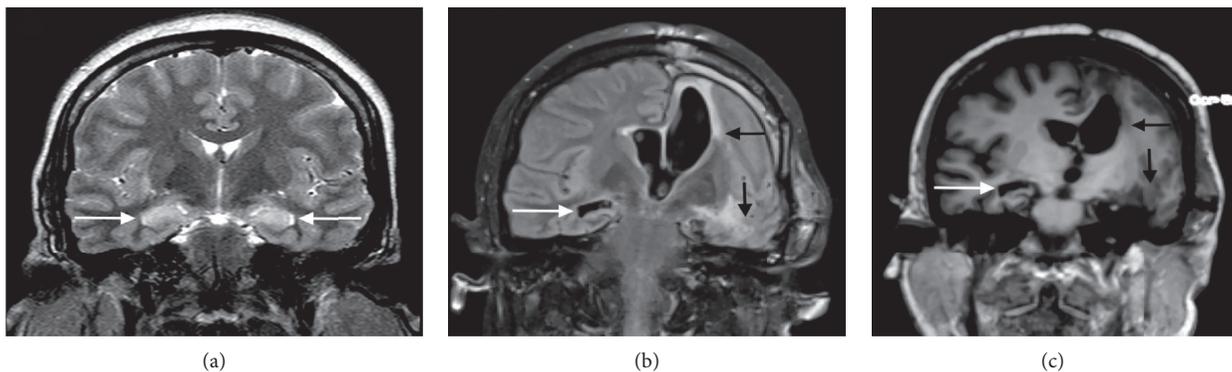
Long-term effect of status epilepticus. A previously healthy young woman presented with a new-onset refractory status epilepticus originating from the left hemisphere. Her initial MRI scan showed bilateral hippocampal swelling with an increased signal on the coronal FLAIR image (white arrows in (a)). Due to prolonged refractory status epilepticus, she underwent acute palliative resective surgery with removal of her dominant epileptic foci in the left frontal and temporal lobes. A repeat MRI four months later ((b) coronal FLAIR image and (c) noncontrasted T1W) showed postsurgical changes on the left (black arrows in (b) and (c)) with marked atrophy of the right hippocampus (white arrows in (b) and (c)).
